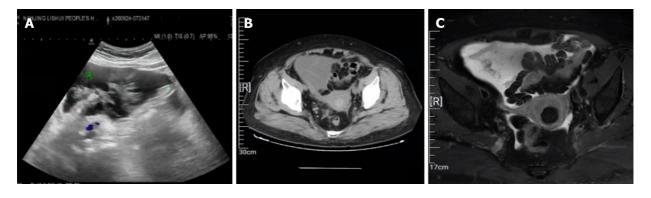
Preoperative examination of the mass. A: Ultrasound; B: Computed tomography; and C: Magnetic resonance imaging.
